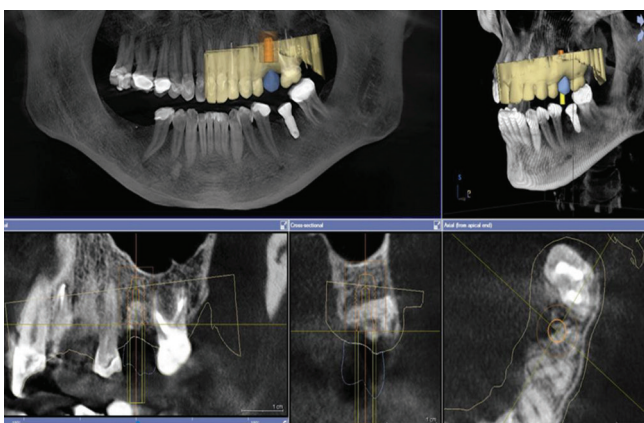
Shows various views of cone beam computed tomography used in implant planning
